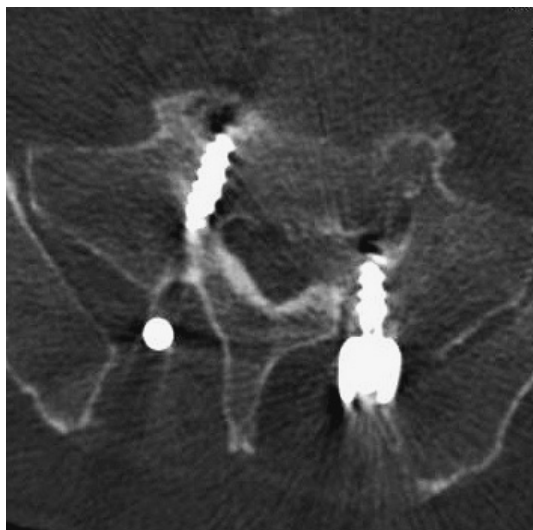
The axial view of CT shows pedicle screw malposition.
